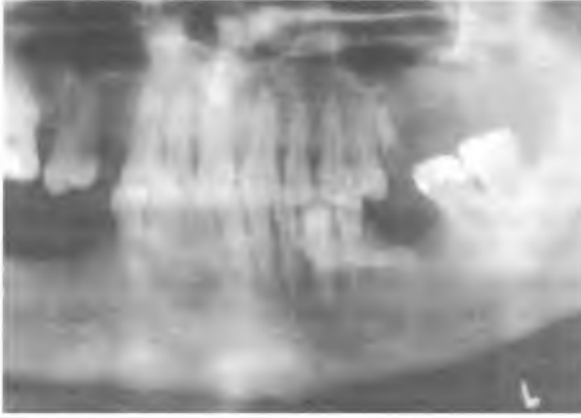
X-ray panoramic of the mandible localization of the sialolith
